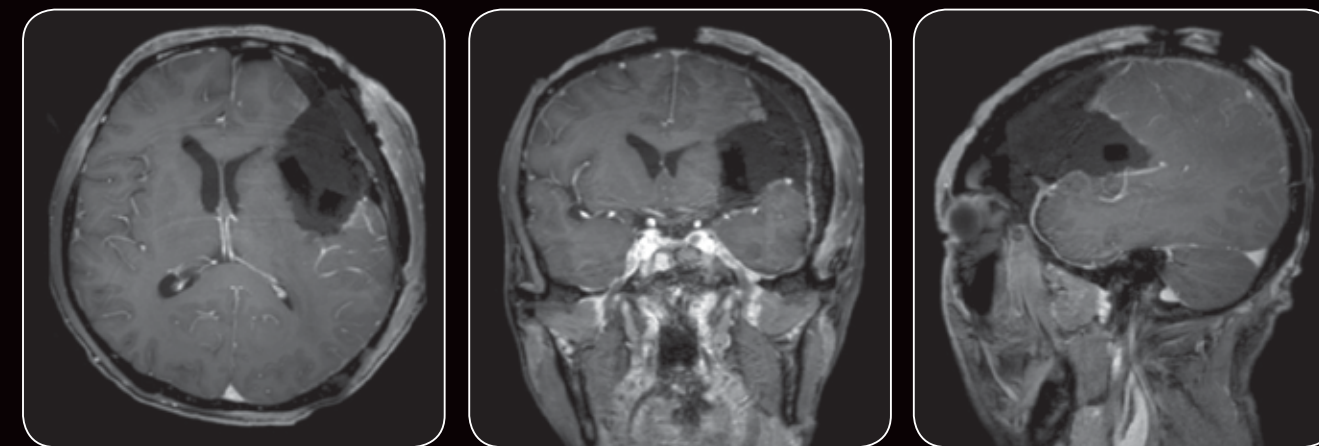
Patient with left frontal glioblastoma. Pre-operative images (top row) help with pre-surgical planning. Intra-operative MR images (left) show survival of the tumor. Post-operative MR (bottom row) confirmed completeness of tumor removal.
